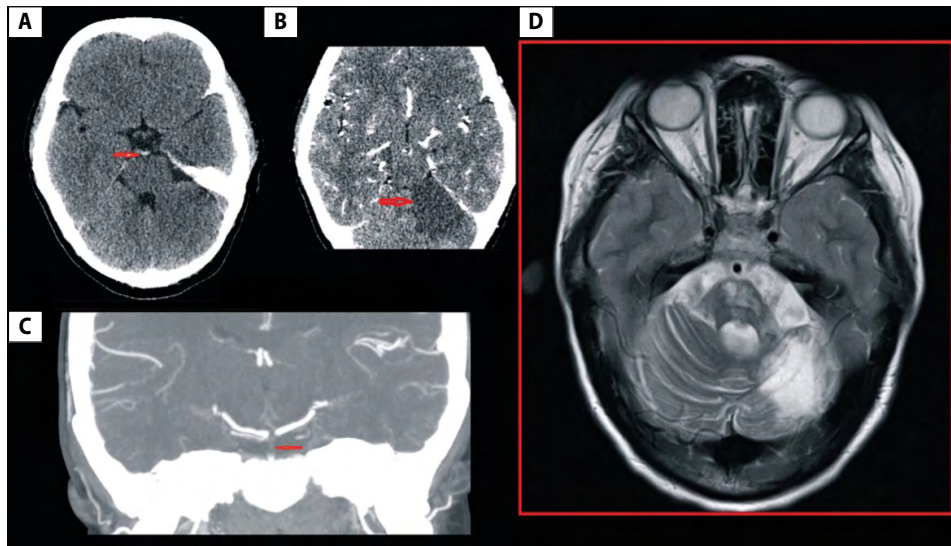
Neuroimaging examinations performed at Accident & Emergency Department of a district local hospital, and an ambulatory follow up two years after the onset of symptoms. A. Head Computed Tomography (CT) scan: hyperdensity of the basilar artery and an early signs of the left cerebellar hemisphere ischemic stroke; B. Head Angio-CT scan: irreversible left cerebellar hemisphere damage – ischemic stroke; C. Head Angio-CT scan: 9 mm in long axis thrombus in the basilar artery. Posterior cerebral arteries were supplied by posterior communicating arteries; D. Brain MRI (2 years after the stroke): malacic lesions in the upper part of the left cerebellar hemisphere, in middle cerebellar peduncle, in the central part of the pons and partially in the medulla (courtesy of Helimed-Diagnostic imaging)
